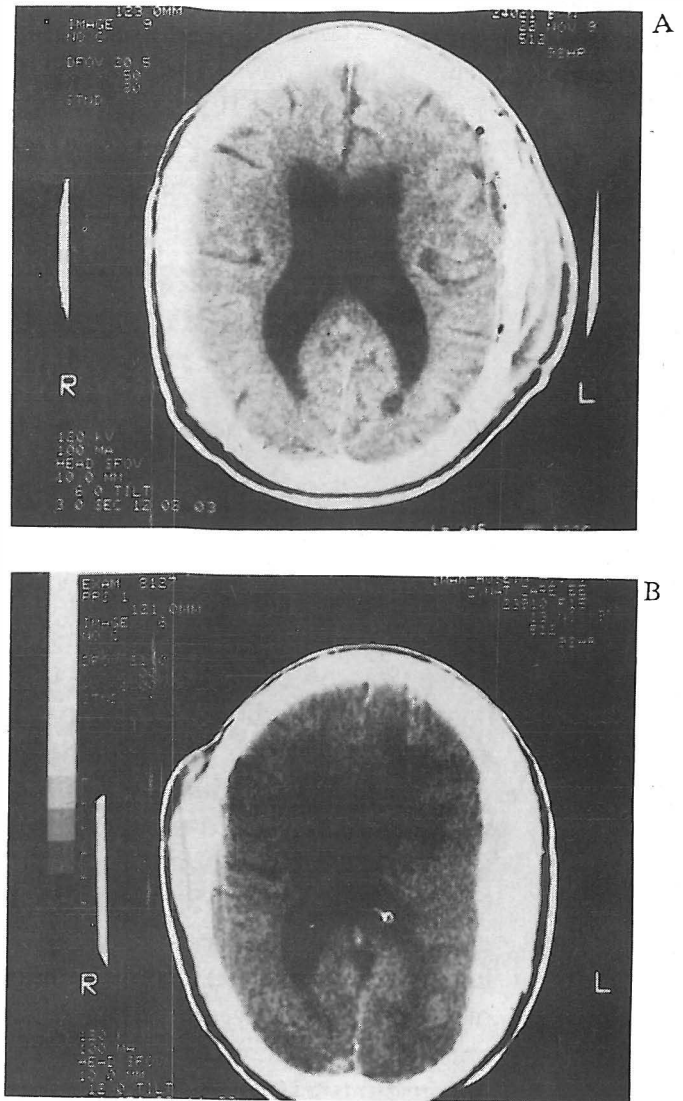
A. Axial non-enhanced CT scan demonstrating left-sided acute subdural hematoma with equivalent midline shift. The patient was a victim of a car accident and had severe head injury. B. Postoperative CT scan. The hematoma has been evacuated and there is no mass effect.
